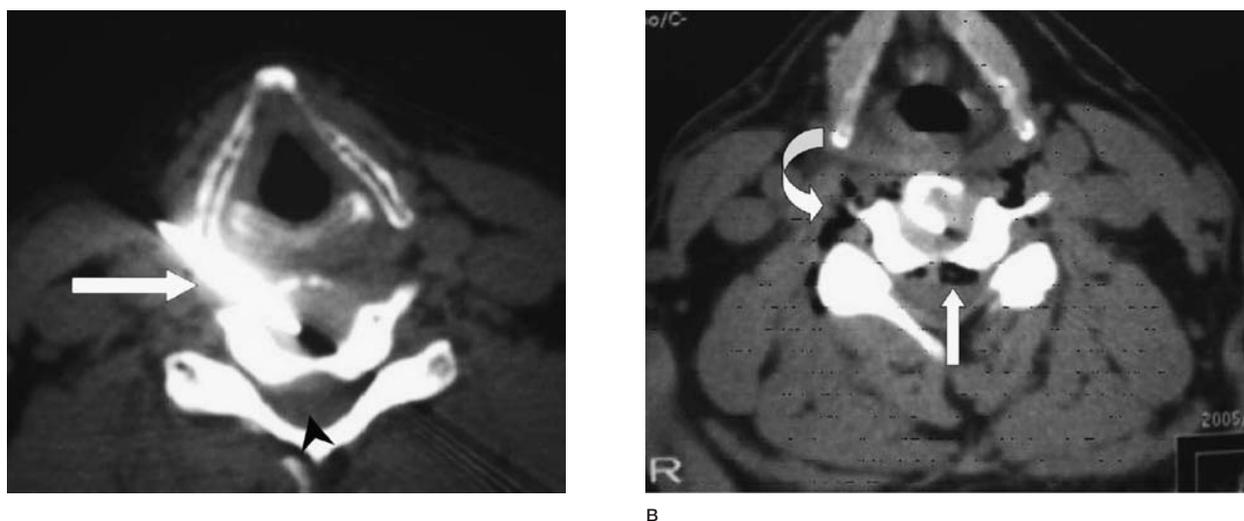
Images in a patient with C4-C5 disk bulging (sympathetic type). A) Precontrast CT image at the C4-C5 level shows disk bulging (*black arrowhead*); the needle was introduced into the disk (*white arrow*) through a right anterolateral approach before ozone injection. B) After injection of ozone, CT shows ozone dispersion into the anterior peridural space (*white arrow*) and bilateral paraspinous tissue (*white curved arrow*).
